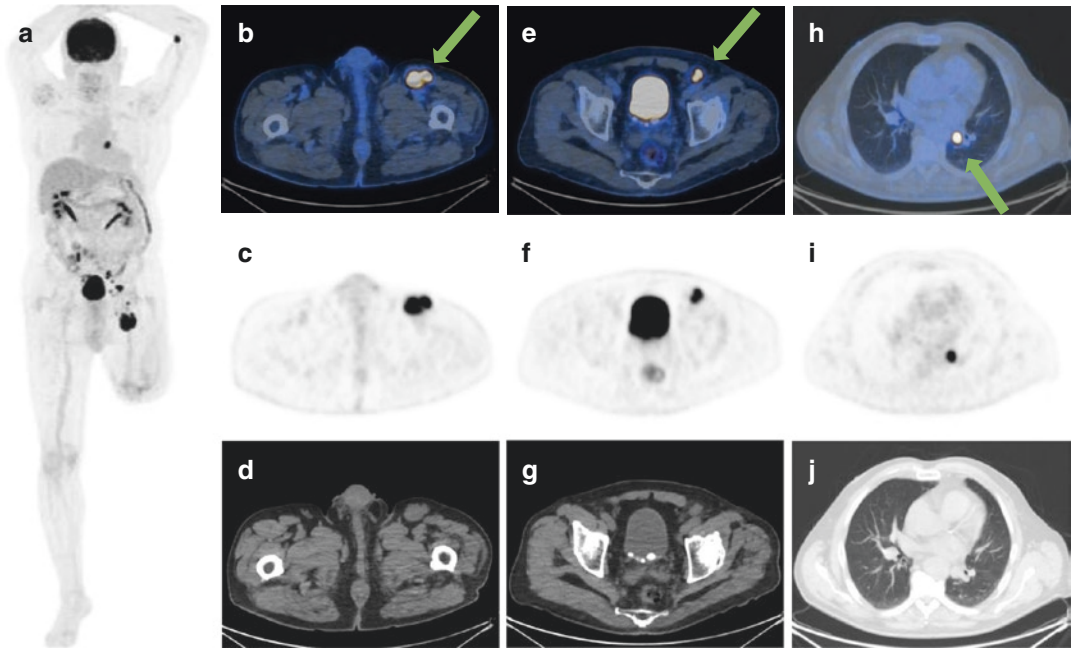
(a) FDG PET/CT after gemcitabine (October 2018): There is reduction in number and tracer uptake in the hypermetabolic lesions previously described in the left
